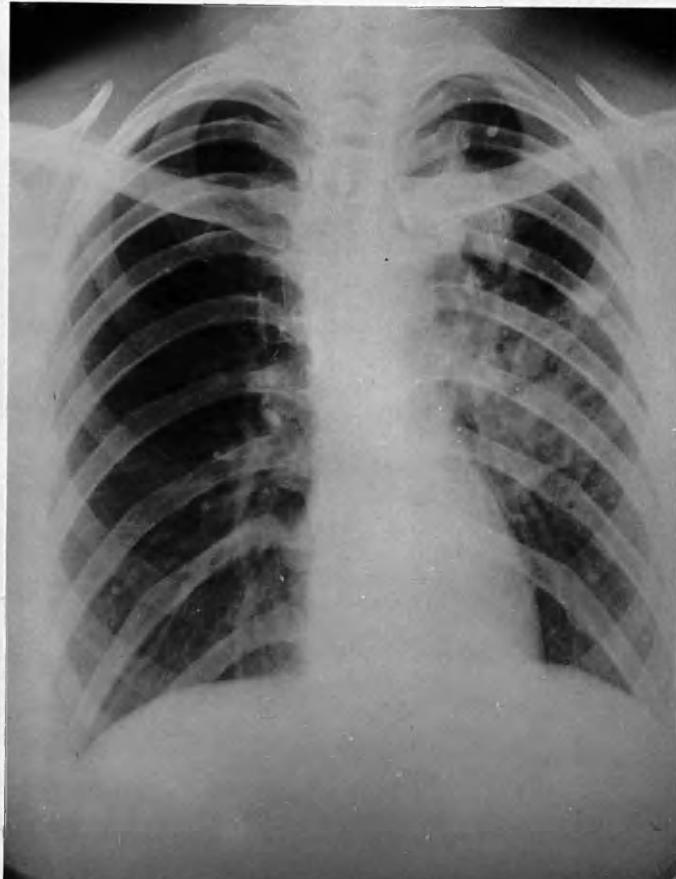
Radiograph taken on 26.1.52. There is now widespread, diffuse shadowing in the left mid- and lower zones, representing acute bronchogenic dissemination of the disease. In this case such an incident occurred on three occasions before the lesion was finally resected.
